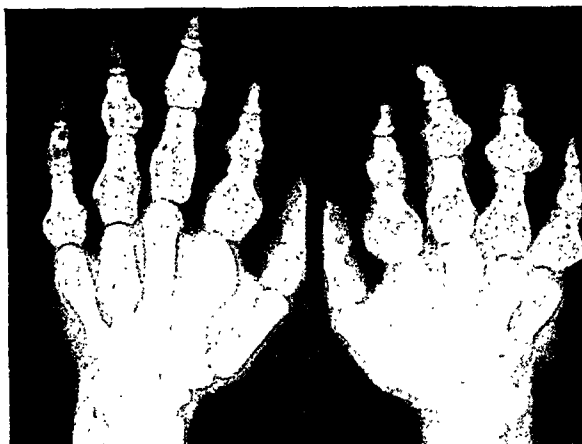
Roentgenogram taken in December 1944, showing multiple chondromata involving the metacarpals and proximal and middle phalanges. Compare with Figure 4.
